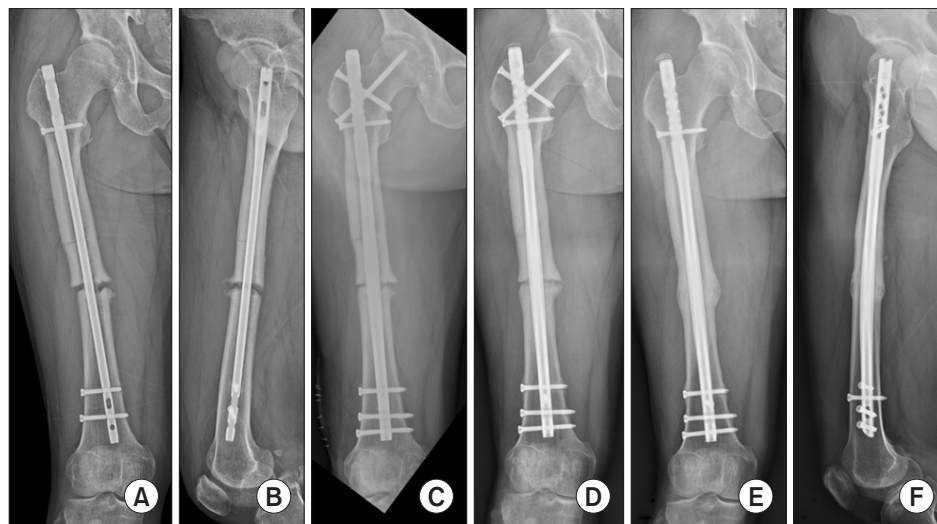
Femoral shaft nonunion in a 44-year-old male patient treated with exchange nailing via the statically locked mode (patient 3 in Table 2). (A, B) Anteroposterior and lateral plain radiographs 7 months after the initial surgery revealed nonunion with a fracture gap and callus-to-diaphysis ratio of 1.21. (C) Postoperative radiograph after exchange nailing with the statically locked mode shows that the fracture gap is diminished by the back-striking technique during exchange nailing. (D) Plain radiograph at 6 months after exchange nailing showing an increase in the callus size but no bridging of callus. The patient complained of persistent pain at the nonunion site; therefore, subsequent dynamization was performed by removal of the proximal 2 static interlocking screws. (E, F) Plain radiographs at 1 year after dynamization revealed complete bone healing without apparent shortening.
